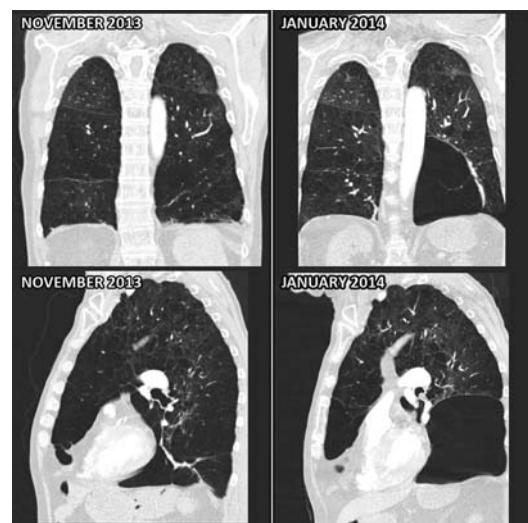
Unenhanced axial high-resolution CT. Interval development of an 11×9×11 cm bulla in the left lower lobe over a 2-month interval. Background lung parenchyma demonstrating centrilobular and pan-acinar emphysema.
